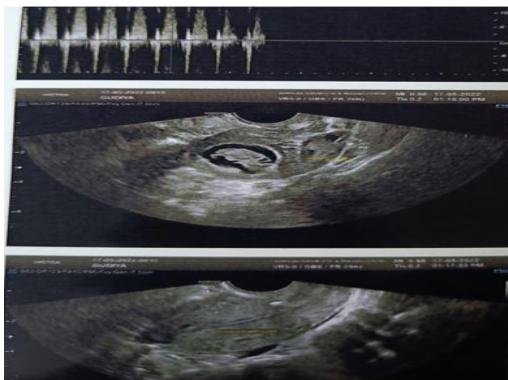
Ultrasound showing empty uterine cavity and extrauterine fetus in left side.
